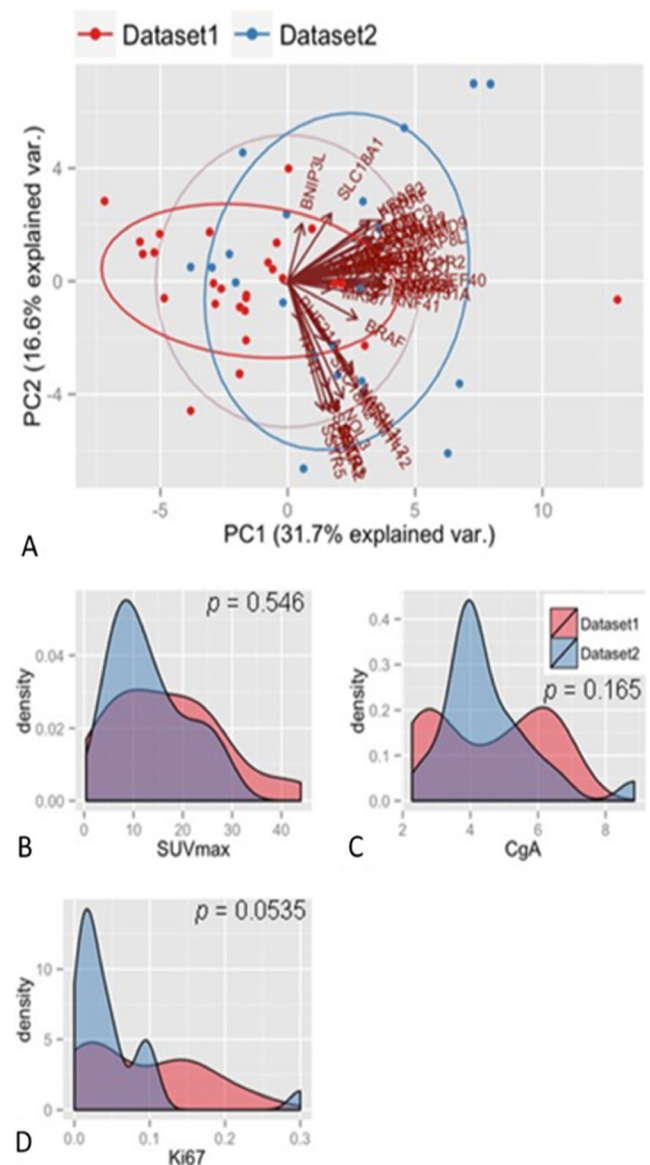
Principal component analysis of data set 1 and data set 2 (a) using expression profiles of 51 marker genes. One outlier sample was excluded. Distribution densities of SUV_{max} (b), CgA (c), and Ki-67 (d) in data sets 1 and 2 confirmed the comparability of SUV_{max} but not of Ki-67 or CgA
